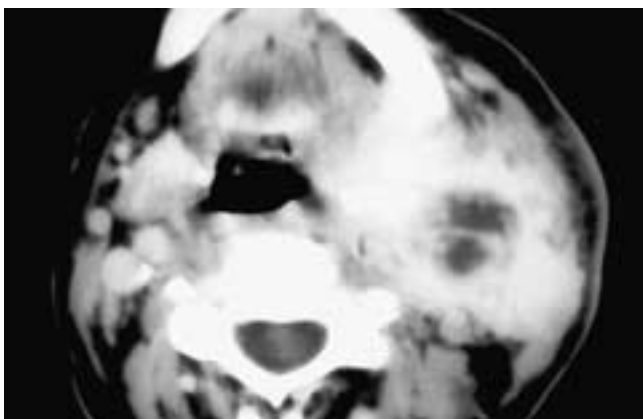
Axial contrast-enhanced CT scan shows a large, infiltrating, necrotic mass that invades the left parotid gland, adjacent neck soft tissues, and the submandibular gland. There are central areas of necrosis. This patient had metastatic breast carcinoma.
